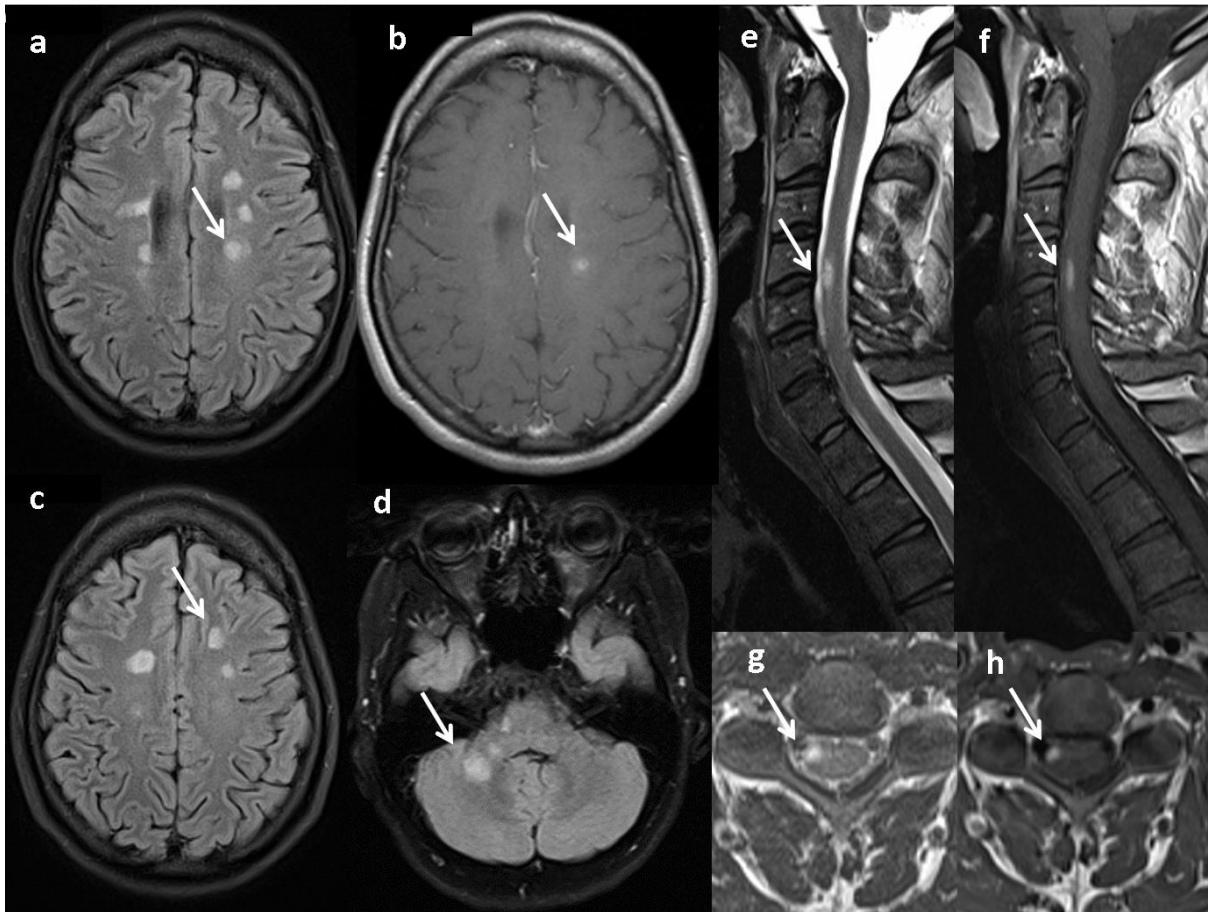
Locations of typical multiple sclerosis lesions in the brain and spinal cord indicated by white arrows. Axial brain MRI scans showing multiple periventricular lesions (a) with contrast enhancement of one lesion (b), juxtacortical lesions (c) and infratentorial lesions (d). Sagittal (e,f) and axial (g,h) scans with a cervical spinal cord lesion showing contrast enhancement in (f,h)
